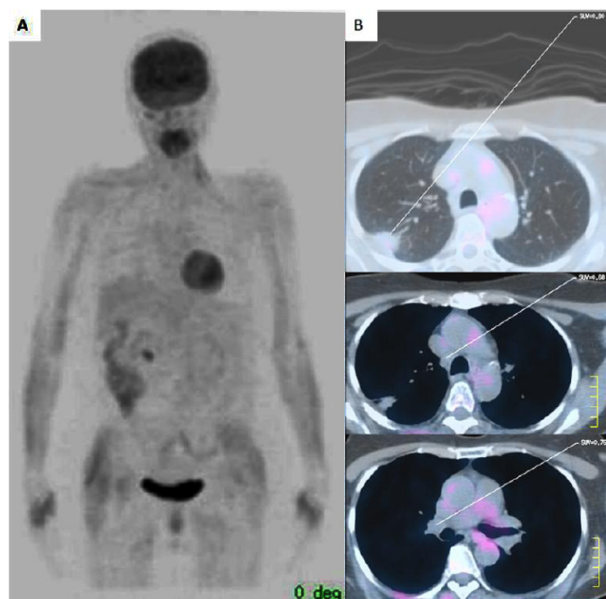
(A-B) - Post-treatment positron emission tomography / computed tomography (PET-CT) (A) PET whole body image showing absence of areas of anomalous concentration of 18-fluorodeoxyglucose (18-FDG). (B) PET-CT cross-sectional image showing normal concentration of 18-FDG in the residual pulmonary mass, with maximum SUV of 0.80; right paratracheal enlarged lymph node, with maximum SUV of 0.68; and right perihilar enlarged lymph node, with maximum SUV of 0.68.
